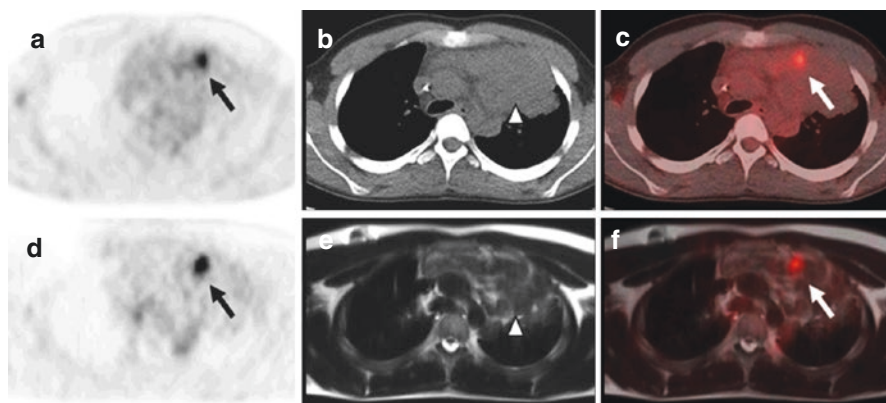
Comparison of simultaneous FDG-PET/MRI with FDG-PET/CT in an 18-year-old male with large B-cell lymphoma for distinguishing fibrosis from viable lymphoma. The PET/MRI was performed immediately following the PET/CT using the same dose of FDG. FDG-PET/CT (a–c) and simultaneous whole body FDG-PET/MRI (d–f) demonstrate a large anterior mediastinum soft tissue mass (*arrow heads*) with a focus of increased FDG activity (*arrows*) suspicious for viable tumor. The remaining mass does not demonstrate increased FDG metabolic activity and likely represents scarring/fibrosis (*arrow head*). (a) FDG-PET from PET/CT acquisition; (b) CT mediastinal window; (c) fused FDG-PET/CT; (d) FDG-PET from PET/MRI acquisition; (e) T2 single shot fast spin echo; (f) fused FDG-PET/MRI
